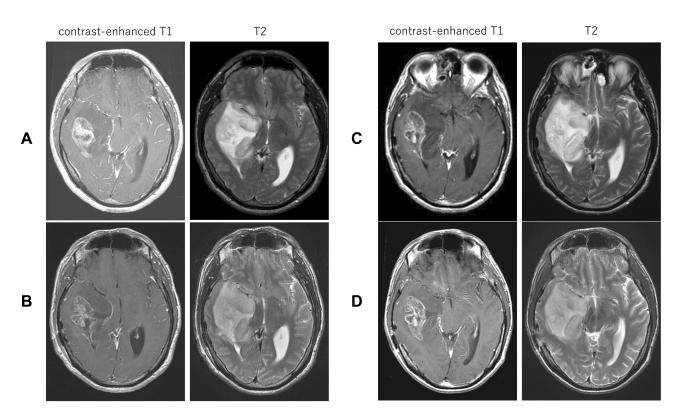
Magnetic resonance imaging (MRI) showing 5×3.5 cm abnormal nonuniformly contrasted mass with hypointensity on T_1 -weighted image (left) and with hyperintensity on T_2 -weighted image (right) in the right temporal lobe. (A) MRI at first consultation; (B) MRI after MPV administration (at day 17 after admission); (C) MRI after FCR administration (at day 34 after admission); (D) MRI after Ibr administration (at day 54 after admission).
